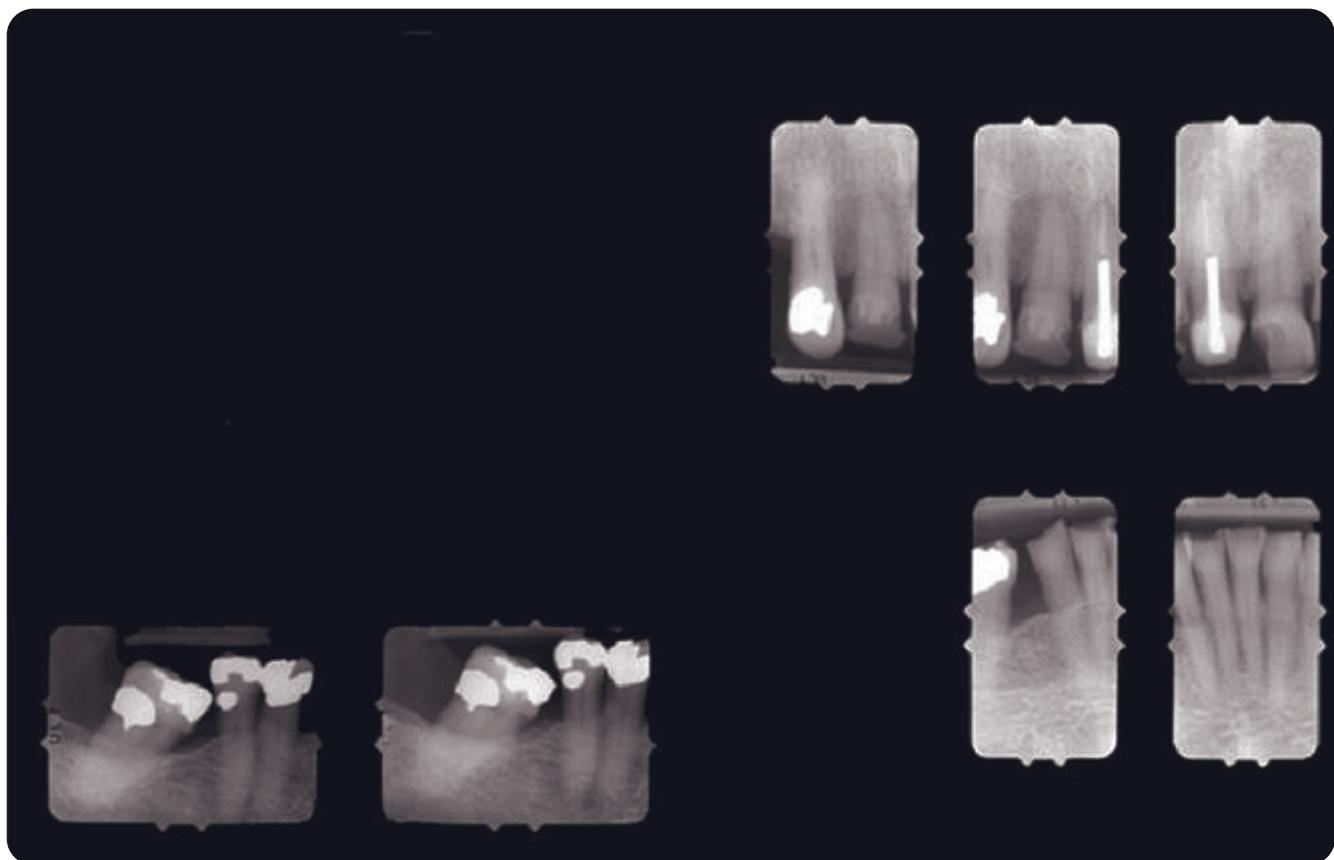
Preoperative radiographs, right side.
